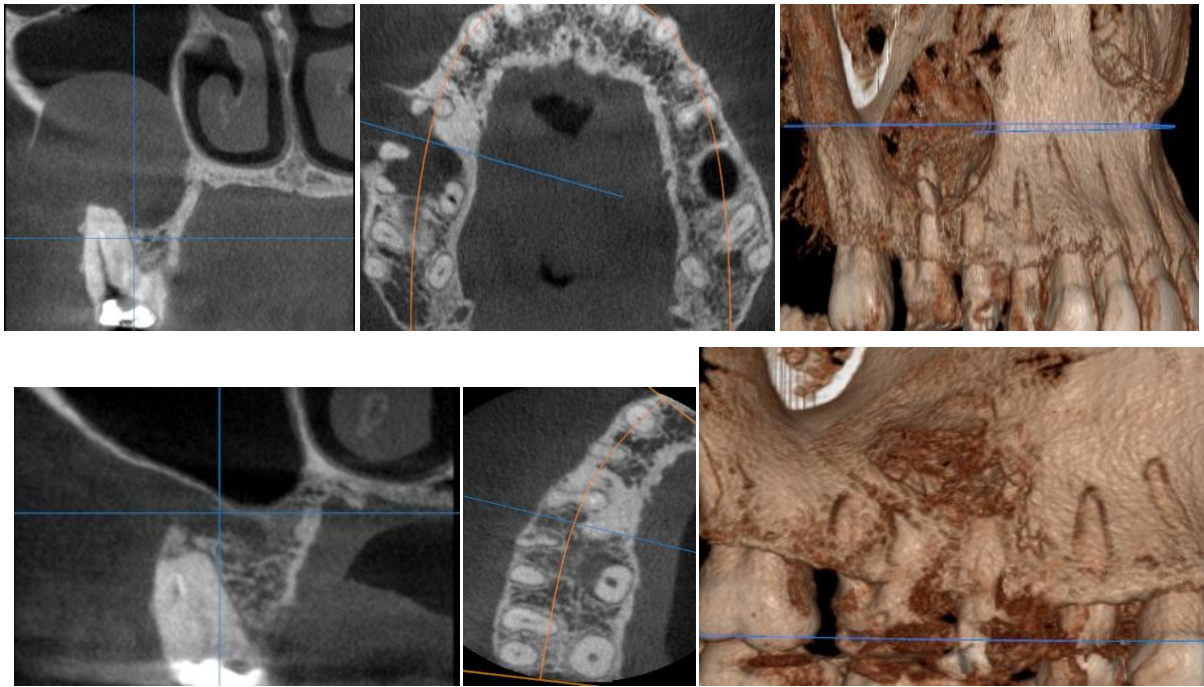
The multiplanar and 3D CBCT- scans in a preoperative case of right antero-lateral maxillary region inflammatory radicular cysts with maxillary sinus involvement and the same examination done 12 months after surgical removal with bone repair revealed
